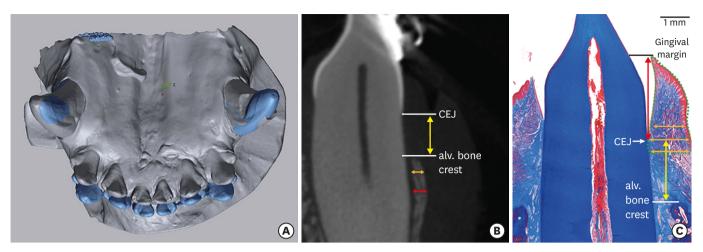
Cast, radiographic, and histomorphometric analyses. (A) A cast analysis was performed by superimposing pairs of scan files of cast models fabricated in the presurgical state (gray) and at 24 weeks post-surgery (blue). (B) Linear measurements (mm) made using micro-computed tomography (yellow arrow, vertical distance from the CEJ to the alveolar [alv.] bone crest; orange arrow, horizontal thickness of bone at 3 mm below the CEJ); red arrow, horizontal thickness of bone at 4 mm below the CEJ). (C) Linear histomorphometric measurements (mm) (red line, epithelium height; yellow line, connective-tissue attachment height; orange lines, horizontal thickness of the gingiva measured at the level of the CEJ and at 0.5 mm above and 0.5 mm below the CEJ; green-dotted closed line, gingiva area measured at 0.5 mm below the CEJ). (C) Linear height (CEJ): (C) CEJ: cementoenamel junction.
